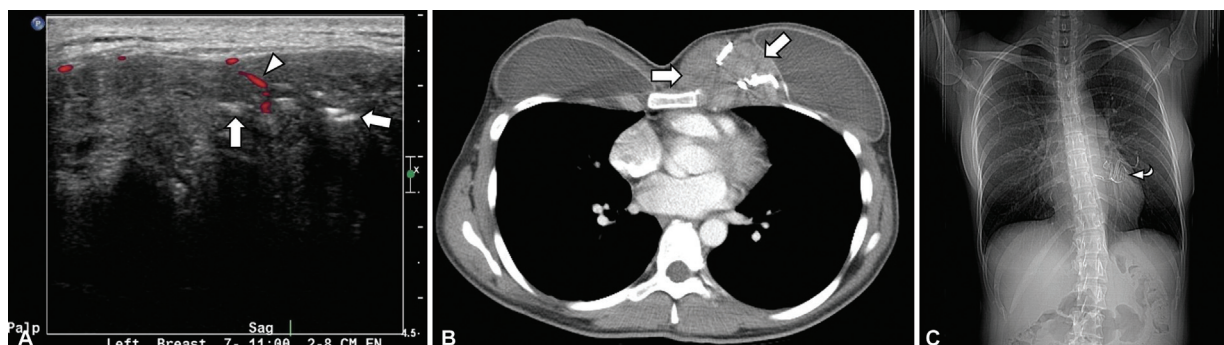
A 34-year-old female presenting with left breast lump 5 few years following breast implant surgery. (A) Ultrasound (US) of the palpable area demonstrates a heterogeneous hypoechoic mass in the medial breast. Scattered echogenic foci of air (arrows) are located within the mass and there is surrounding hyperemia of the adjacent tissues (arrowhead). (B) Axial computed tomography (CT) of the chest with contrast shows an anterior chest wall hyperdense mass along the medial margin of the left breast implant. Linear high density material seen within the mass represents the radiopaque portion of a retained surgical sponge. (C) Scout view from the chest CT shows the entirety of the radiopaque surgical sponge (curved arrow).
